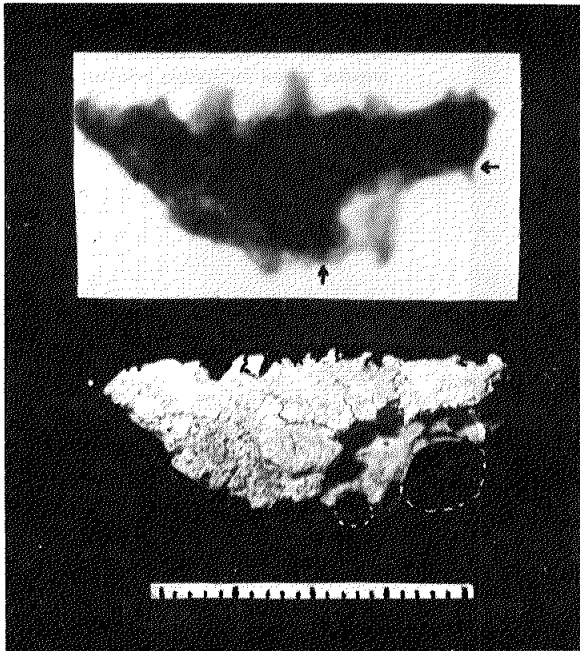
Fragment of parietal bone with partly destroyed outer layer showing the diploe eroded by a larger arachnoid granulation (?), penetrating the inner layer of the vault (see openings completed with dotted lines). Radiograph shows the sharp limitation of this erosion (see arrows). Each stroke of the measure tape indicates one millimeter.
